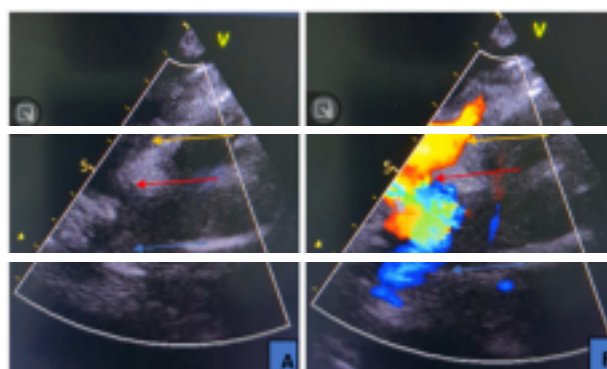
Transthoracic echocardiography image, suprasternal window in two-dimensional mode (A) and with color Doppler (B) showing area of coarctation and flow acceleration (red arrow), left subclavian artery (yellow arrow) and descending aorta (blue arrow) of case N°1.
